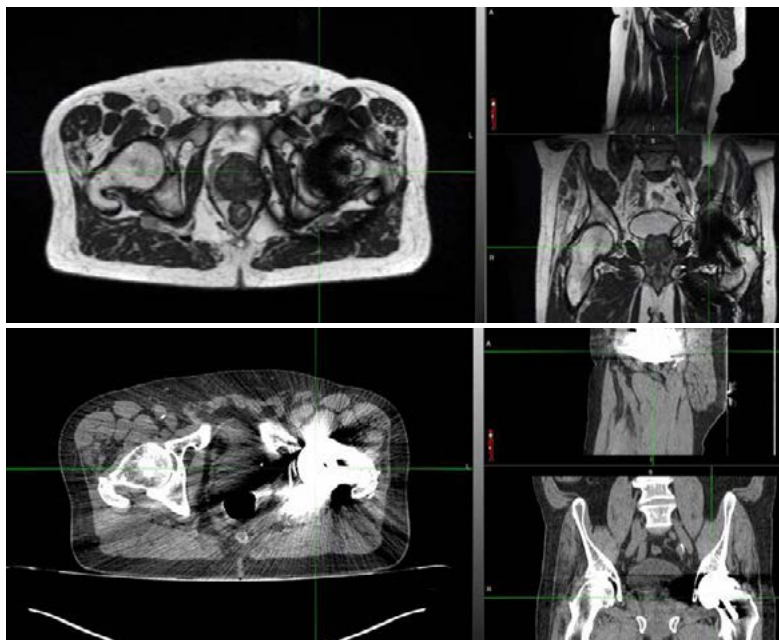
Planning scans of the patient. The top image shows MRI planning images using 0.35 T MRIdian displaying minimal artefact around the left prosthetic hip. The bottom is a CT planning scan of same patient showing significant artefact and obscured prostate views
